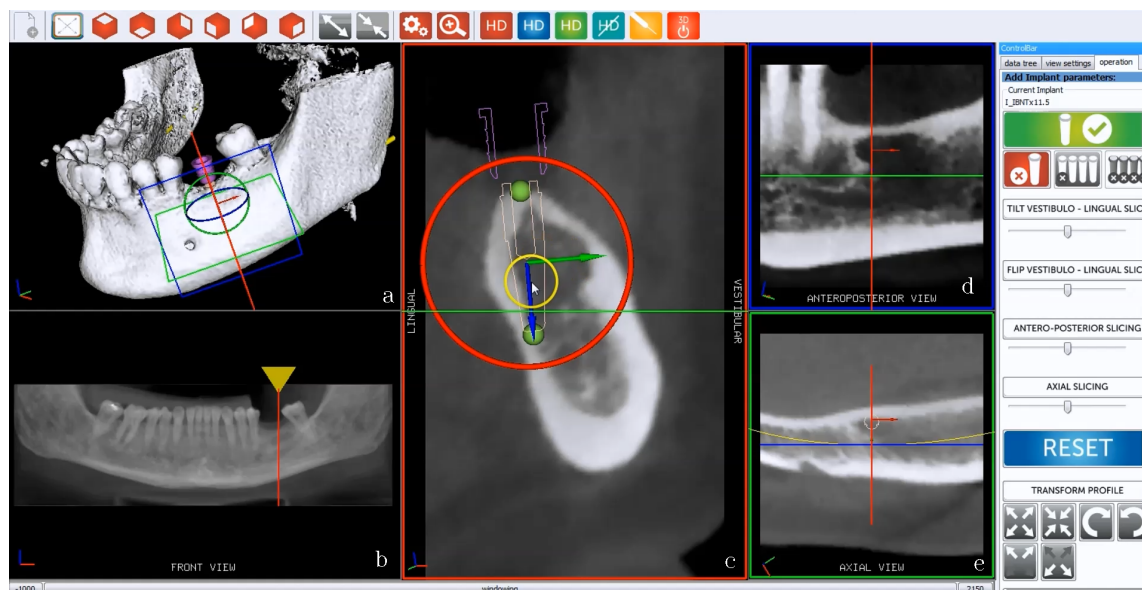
Surgical plan using the developed compound view of the software application, composed of a three-dimensional view (a), a panoramic view (b), a vestibule-lingual volumetric cut (c), an anteroposterior (d) and an axial (e) slice. The central vestibulo-lingual volume slice (c) is moved perpendicularly to the panoramic profile using the yellow handle in the orthopantomographic view (b). Then desired insertion and apex point of the implant is picked in the central slice and as a result the best fitting implant from the library is pre-visualised in place.
